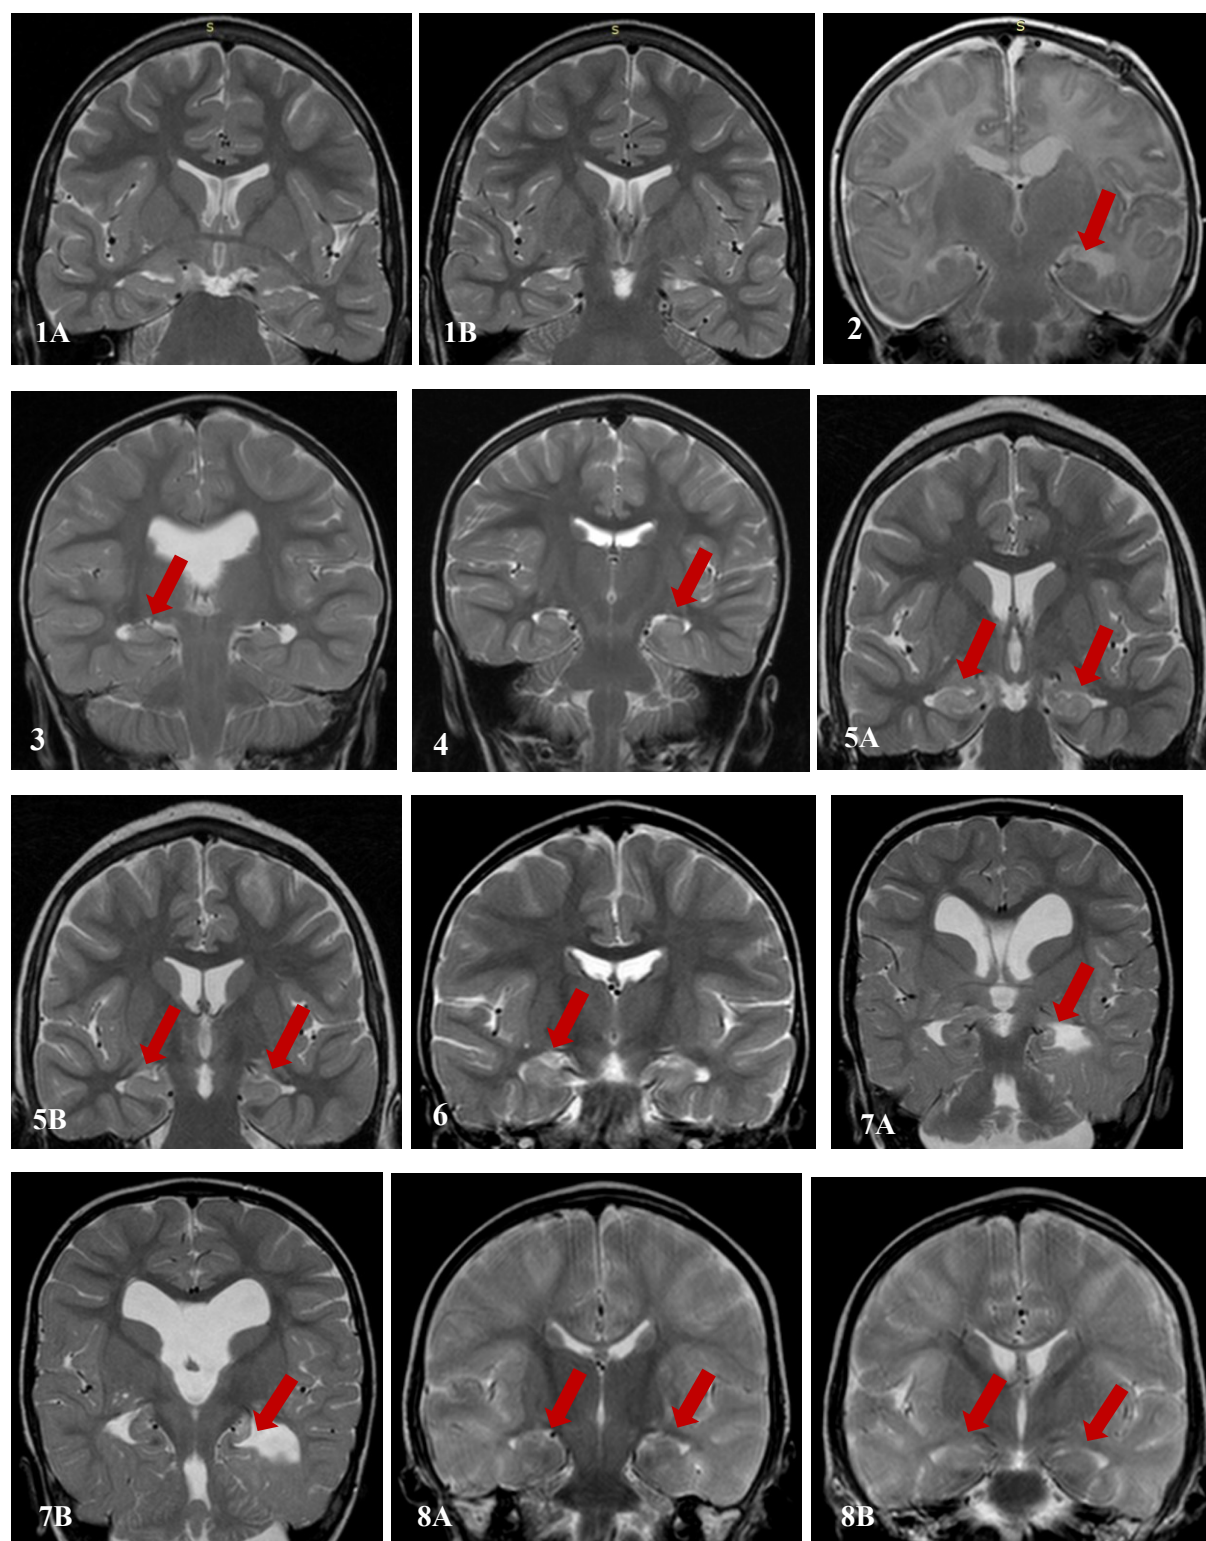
Examples of patients' MRI with normal and increased hippocampal T2Scores. 1A,1B – normal (T2Score=0), 2- equivocal (T2Score=1) on the left, 3 - mildly abnormal (T2Score=2) on
